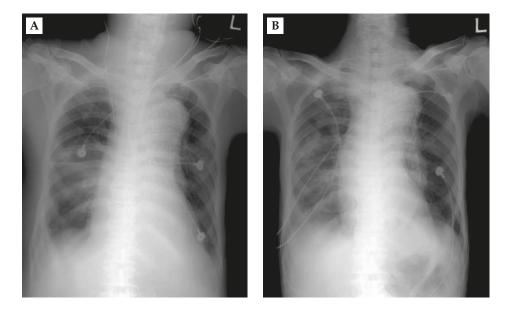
Chest radiographs revealed no change in mediastinal width after: (A) insertion of the right jugular venous catheter, compared with (B) the chest radiograph before the procedure.*
